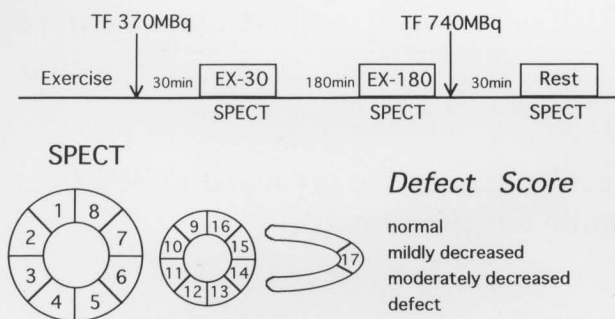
Study protocol (upper). At peak exercise 370 MBq of Tc-99m-tetrofosmin (TF) was injected and SPECT was performed 30 min (EX-30) and 180 min (EX-180) later. After EX-180 imaging, 740 MBq of TF was injected at rest, and SPECT (REST) was performed 30 min later. A 4-point scoring system (lower). The basal and mid left ventricular levels of the short axial view and the apical portion of the long axial view of SPECT were divided into 17 segments. A 4-point scoring system was used to evaluate myocardial uptake in each segment.
